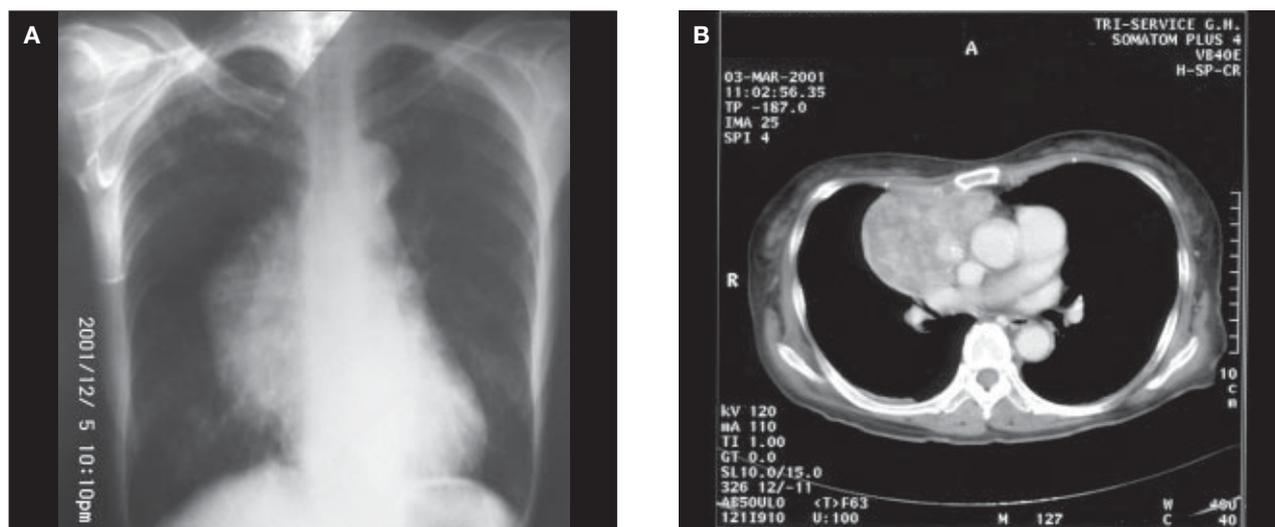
(A) A bulging mass in medial aspect of right hemithorax. (B) Chest computed tomography scan revealed a large lobulated soft tissue mass ($10 \times 9 \times 7$ cm) with multiple nodular and well-enhanced structures.
